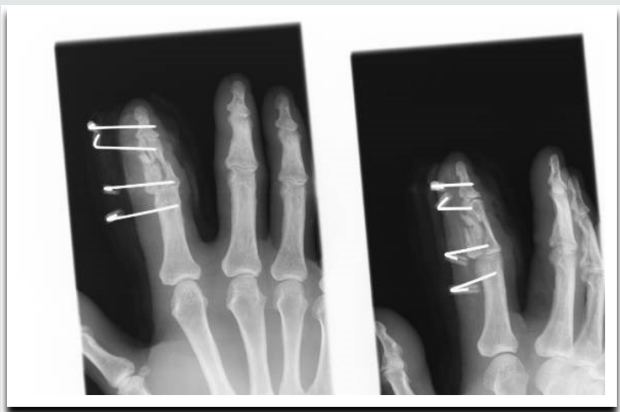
Radiographical aspect after the external fixation of the second "catastrophic" finger.
